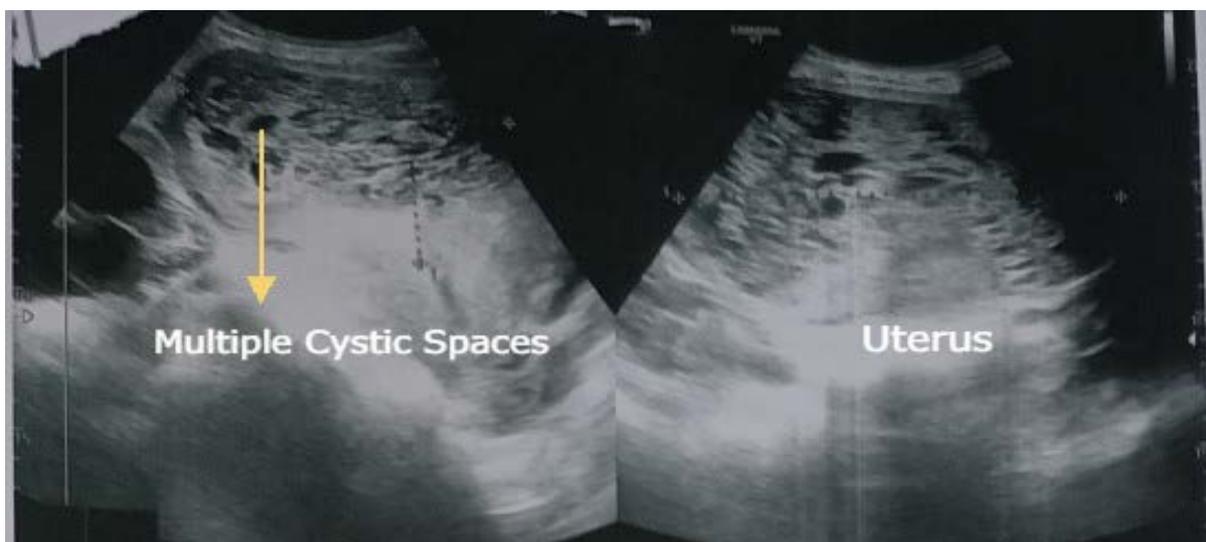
Ultrasonography of abdomen showing bulky uterus containing a hyperechoic structure with multiple cystic spaces within its cavity
